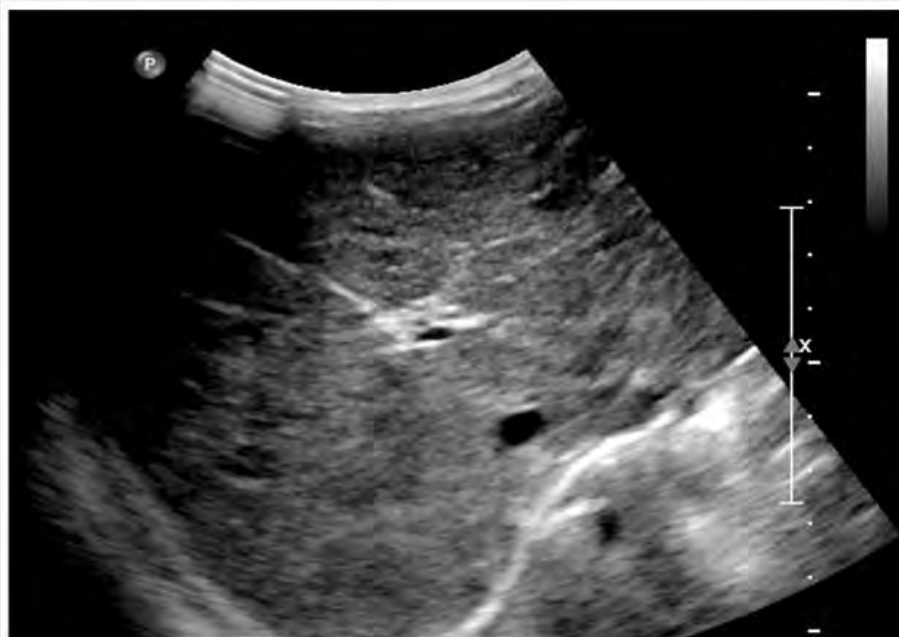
Ultrasound images twenty-four months later: the hypoechoic lesions seem unnoticed.
